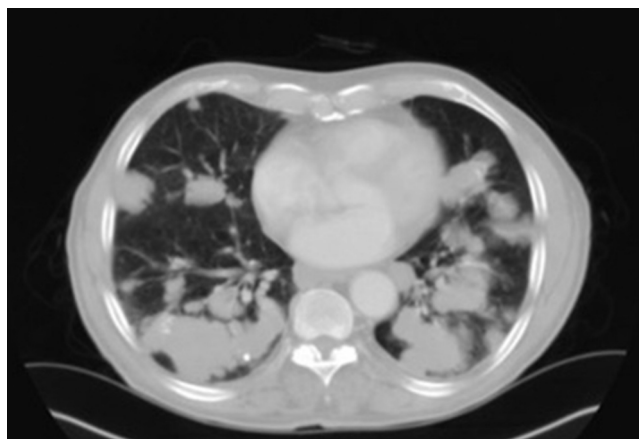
Chest computed tomography showing disperse pulmonary nodules with lobulated borders.
